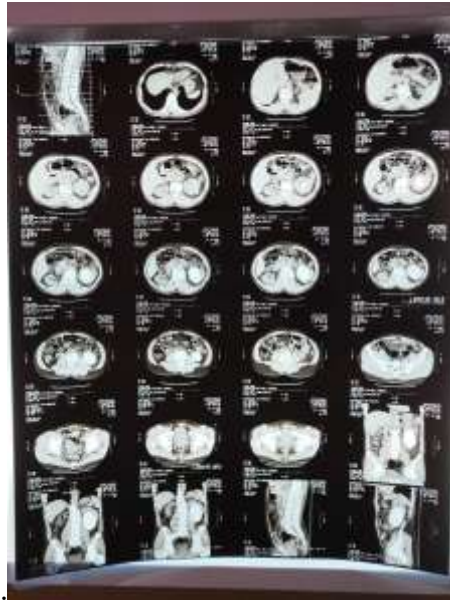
Non-contrast abdominal MSCT scan with axial, coronal, and sagittal reconstructions (original CT scan obtained at RSUD Hajja Andi Depu Hospital).
